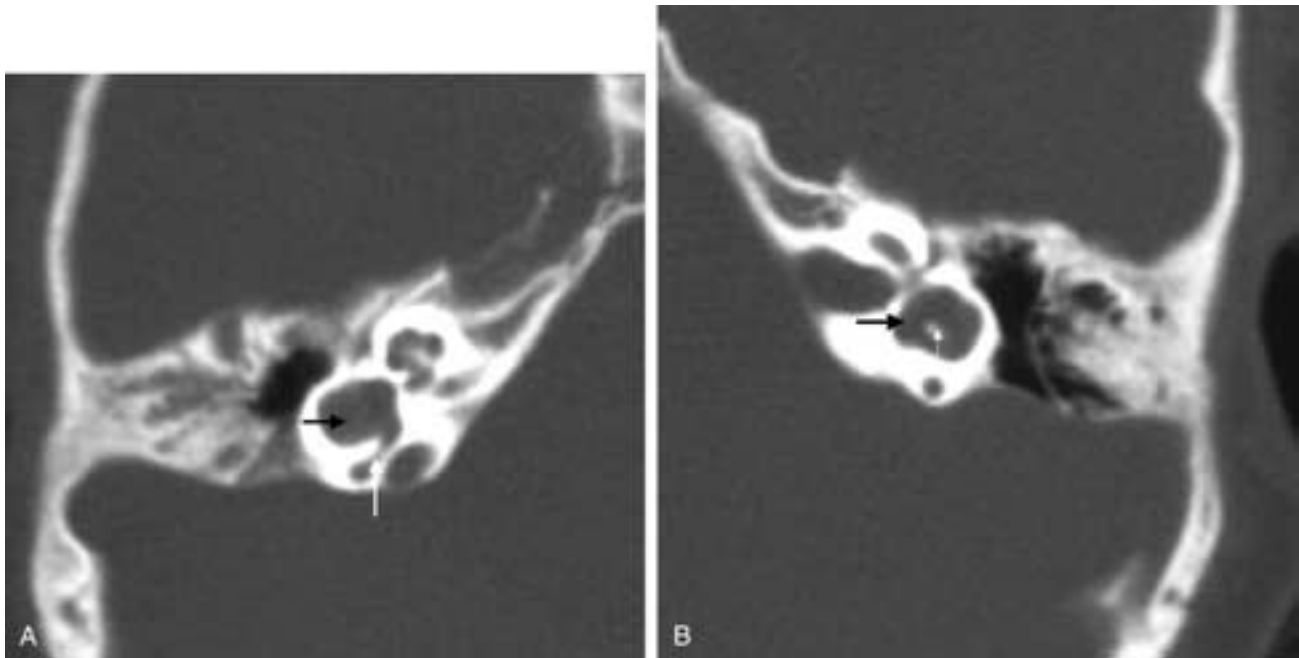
Enlarged vestibules. A, Axial CT image showing complete assimilation of the right lateral semicircular canal into the vestibule (*black arrow*). Note the normal posterior semicircular canal (*white arrow*). B, Axial CT image showing nearly complete assimilation of the left lateral semicircular canal into the vestibule (*black arrow*). Note the small central bony core (*white arrow*).
